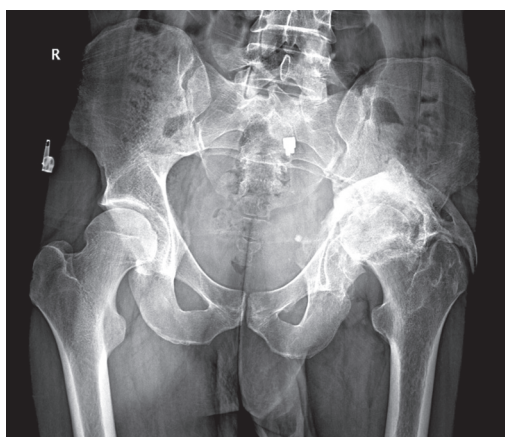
X-ray of a patient 27 y.o. on admission: left-sided 3-stage post-traumatic hip osteoarthritis with cyst-like restructuring and aseptic necrosis of the left femoral head apex, massive paraarticular ossificates, left acetabulum fracture consolidated in the displacement position, consolidated fracture of the left acetabulum posterior wall.
